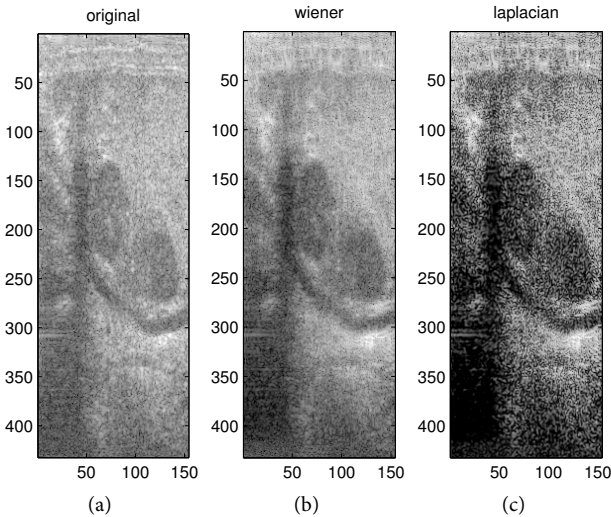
Comparison between wiener and laplacian deconvolution relative to a prostate scan acquired with Trans Rectal Ultrasound (TRUS).
